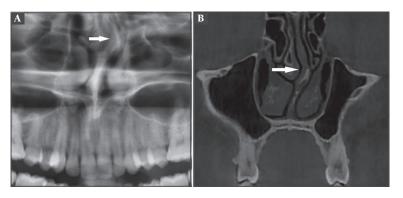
Cropped panoramic radiography (A) and coronal CBCT image (B) show a nasal septal deviation(arrow).
